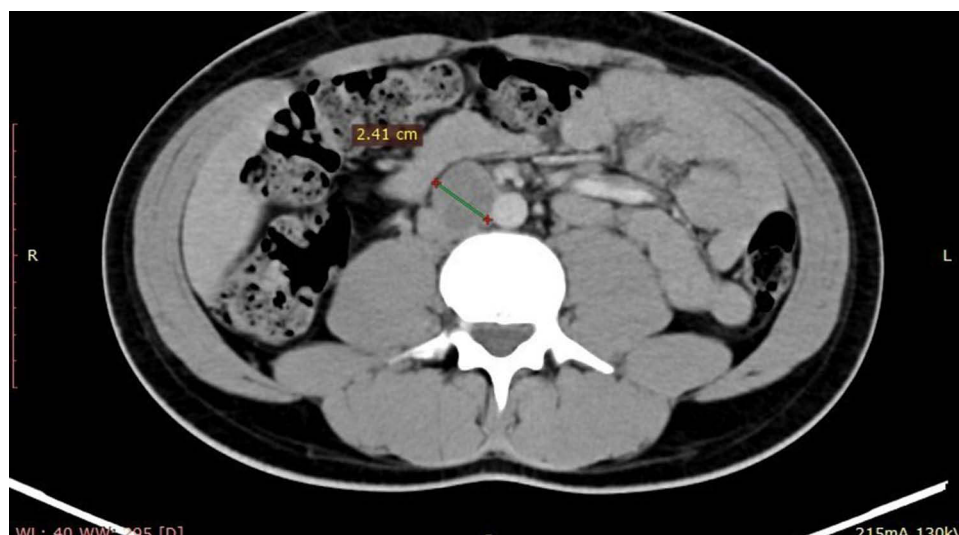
Axial contrast-enhanced CT of the abdomen showing para-aortic lymphadenopathy with a nodal deposit measuring 2.41 cm in short axis.
